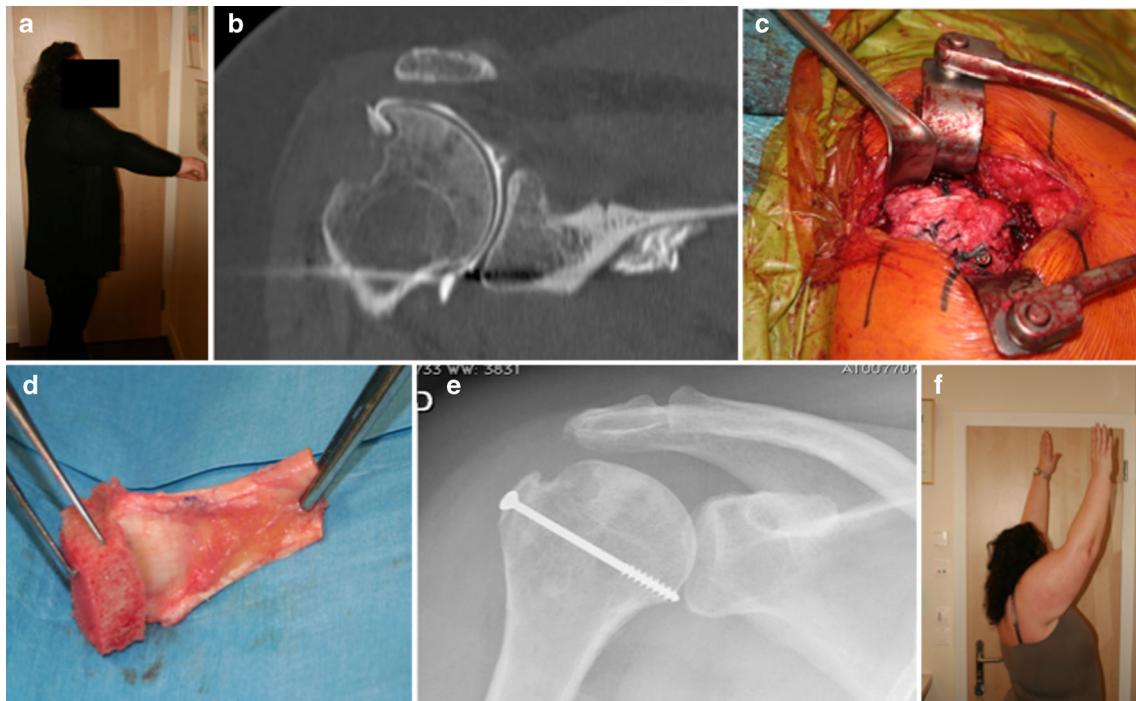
a Example of a 44-year-old woman who sustained a fracture of the greater tuberosity following a right glenohumeral dislocation. An open reduction and stabilization of the greater tuberosity with a “Hawkins” tension band was performed in another institution. The patient presented persistent pain and pseudoparalysis. b The CT scan
